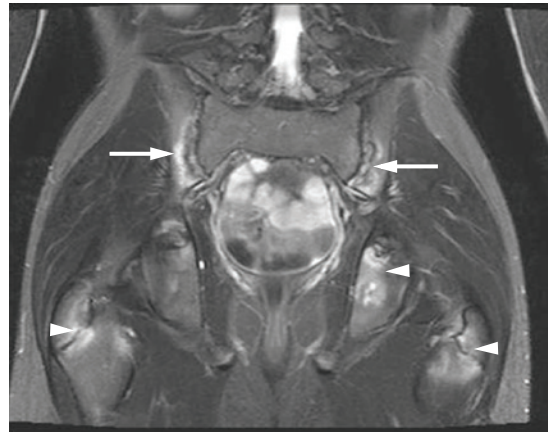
MRI manifestations of juvenile SpA. The image is a STIR sequence obtained in the coronal plane in a 14-year-old boy with ERA (HLA-B27 positive). Fluid and pathology appear bright, as does spinal fluid. Increased signal abnormality is observed around bilateral triradiate cartilages and greater trochanteric apophyses (arrowhead), frequent areas of involvement for ERA. Also, signal abnormality appears on the iliac side of the sacroiliac joints bilaterally around more curvilinear dark sclerotic subchondral areas representing erosions and sacroiliitis (arrows). Abbreviations: ERA, enthesitis-related arthritis; SpA, spondyloarthritis; STIR, short T1 inversion recovery.
